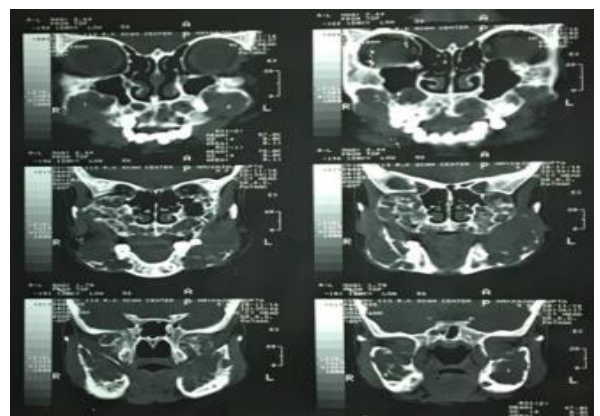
Coronal CT Scan slices.
